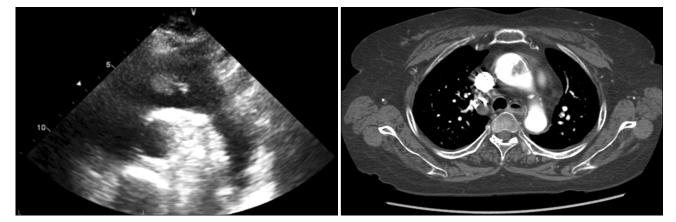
Preoperative TEE and 3D thoracic aorta CT show thrombus in the ascending aorta.
